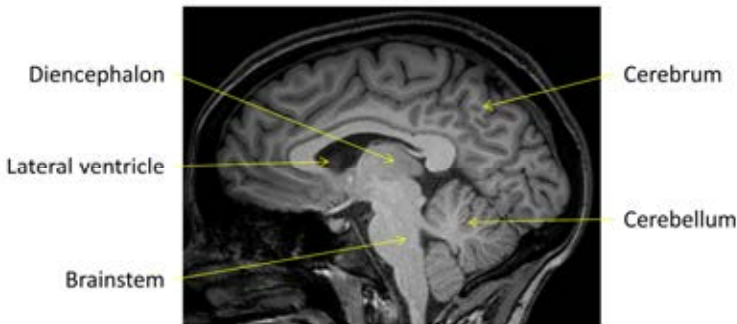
The main parts of the human brain, based on T1-MRI imaging.
